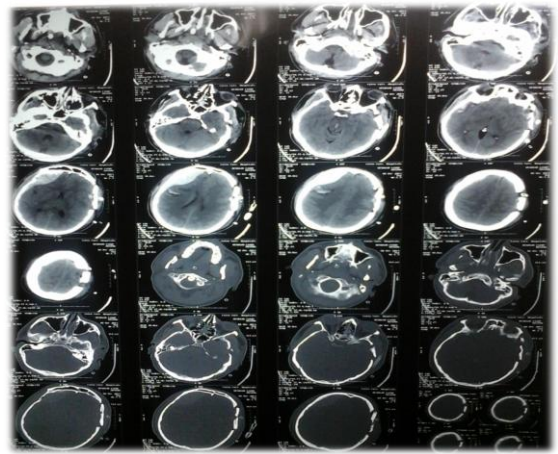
Post-operative CT brain of Case 4 showing RT frontal EDH and hemorrhagic infarction
